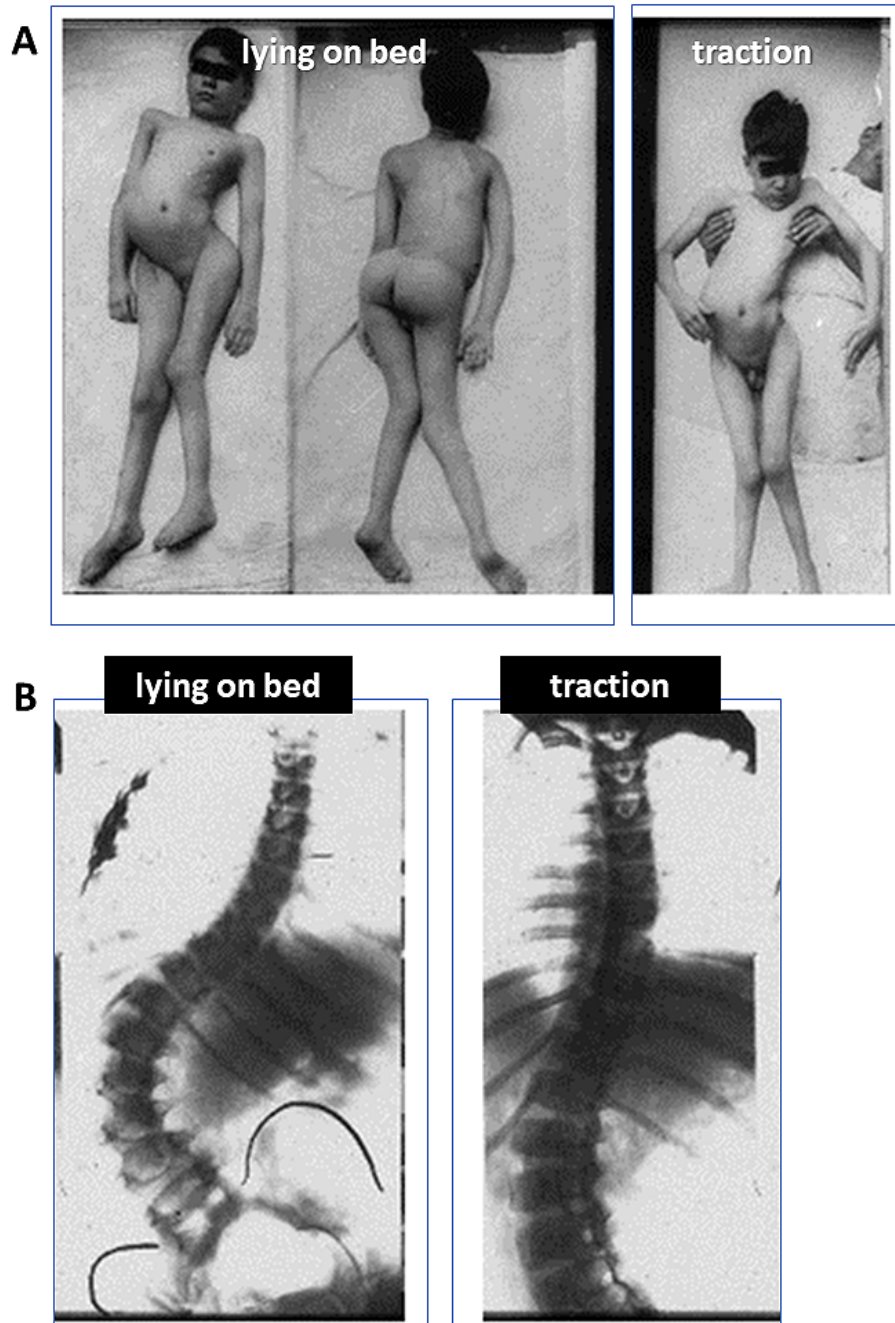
An 11-year-old boy, paralytic spinal deformity due to poliomyelitis. Photos on the bed (A) and X-rays (B).
